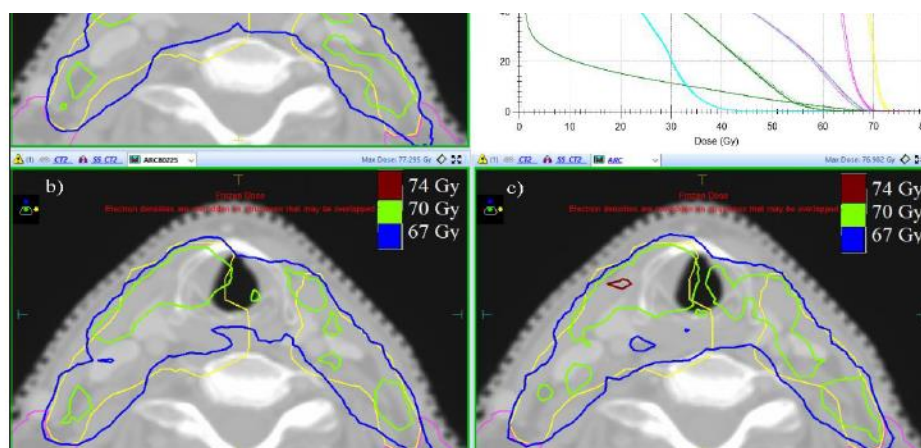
The differences in distribution of 70 Gy isodose in different treatment plans created at CT sensitometry curves of 140 kV 225 mA (a) 80 kV 225 mA (b) reference curve (c) and comparative DVH (d).
